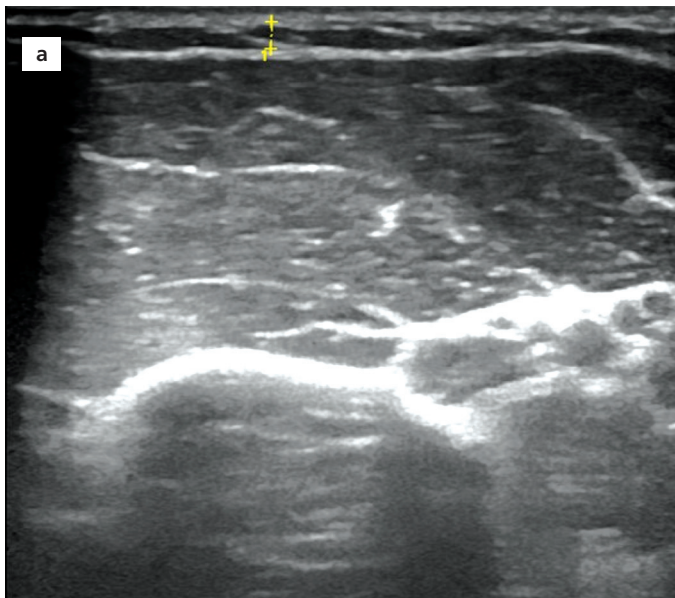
Ultrasound measurements on images. (a) measurement of the subcutaneous adipose tissue of the arm; (b) measurement of the subcutaneous adipose tissue of the thigh; (c) measurement of the umbilical preperitoneal fat (1) and umbilical subcutaneous adipose tissue (2).
